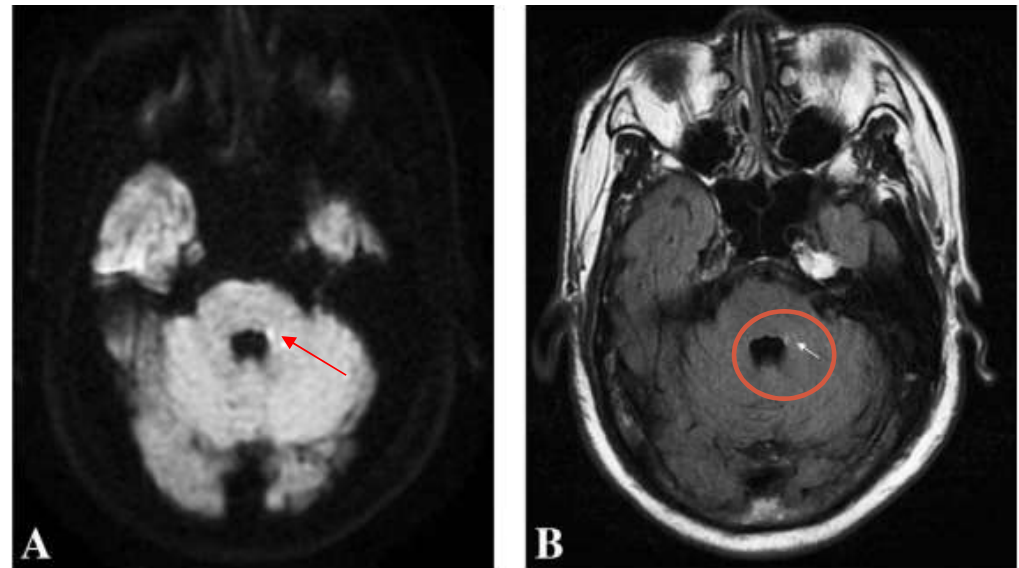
Transverse section of magnetic resonance imaging scan. A small hyperintense signal (arrow) in the left dorsolateral pons on diffusion-weighted image (A) and fluid-attenuated inversion recovery image (B).
